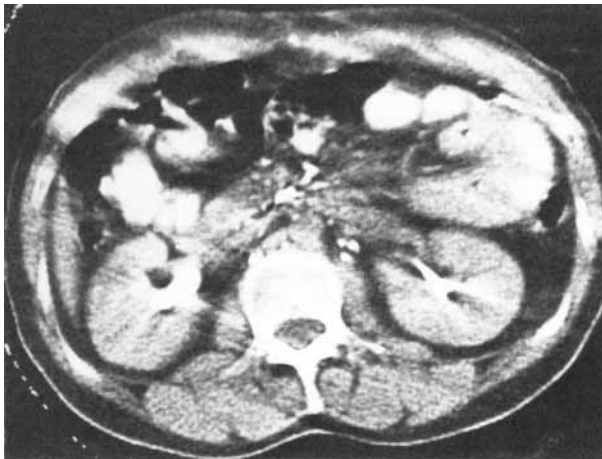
33-year-old. Teratocarcinoma of the left testis with seminomatous areas. Lymphadenectomy demonstrated small metastatic deposits in a few lumboaortic nodes; resection was considered radical by the surgeon. CT scan of the abdomen, one month after lymphadenectomy. Blurring of the retroperitoneal vessels resembling metastatic infiltration.
